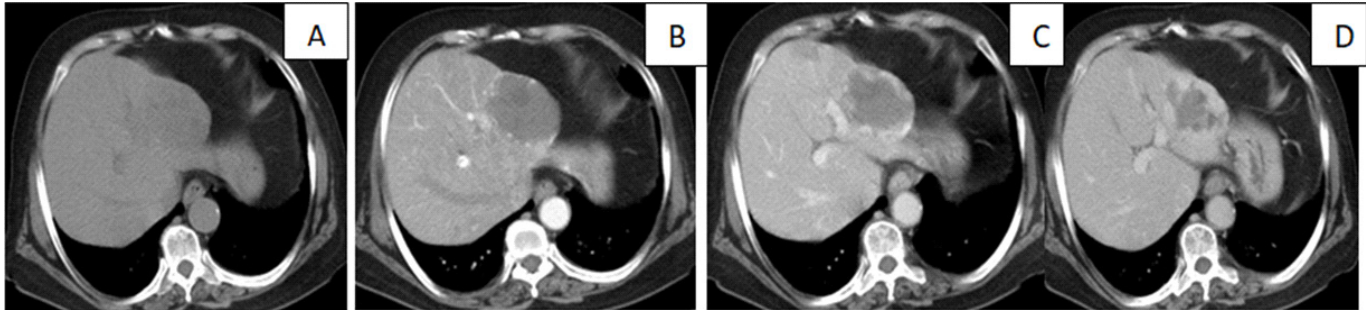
50 year old female was diagnosed of liver lesion on USG underwent CECT for further evaluation, (A) plain CT showing hypodense lesion in left lobe, (B) arterial phase of CECT showed peripheral puddles, (C) venous phases showed filling in of contrast and (D) delayed images showed further centripetal filling of contrast which was suggestive of Haemangioma
